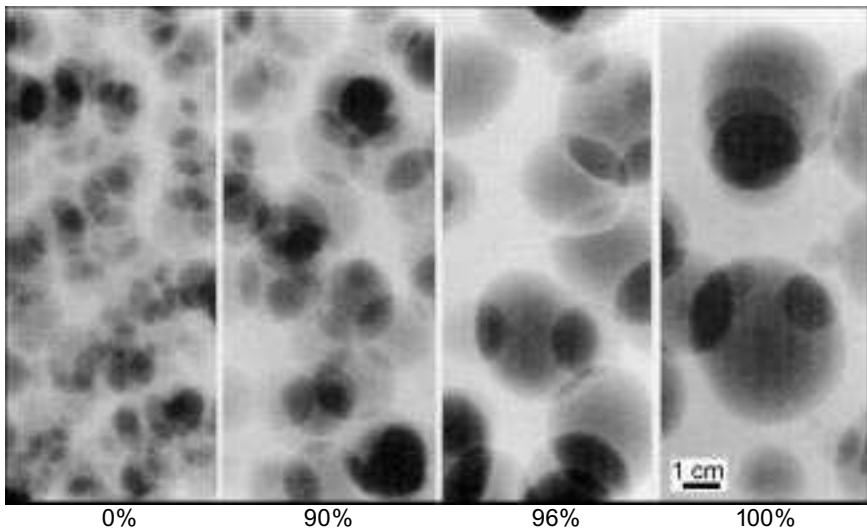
Eye formation in an Emmentaler cheese made with uncentrifuged (0%) or partially (90, 96 or 100% v/v) centrifuged vat milk (source: X-ray by ALP Agroscope Liebefeld-Posieux, CH-3003 Berne).
